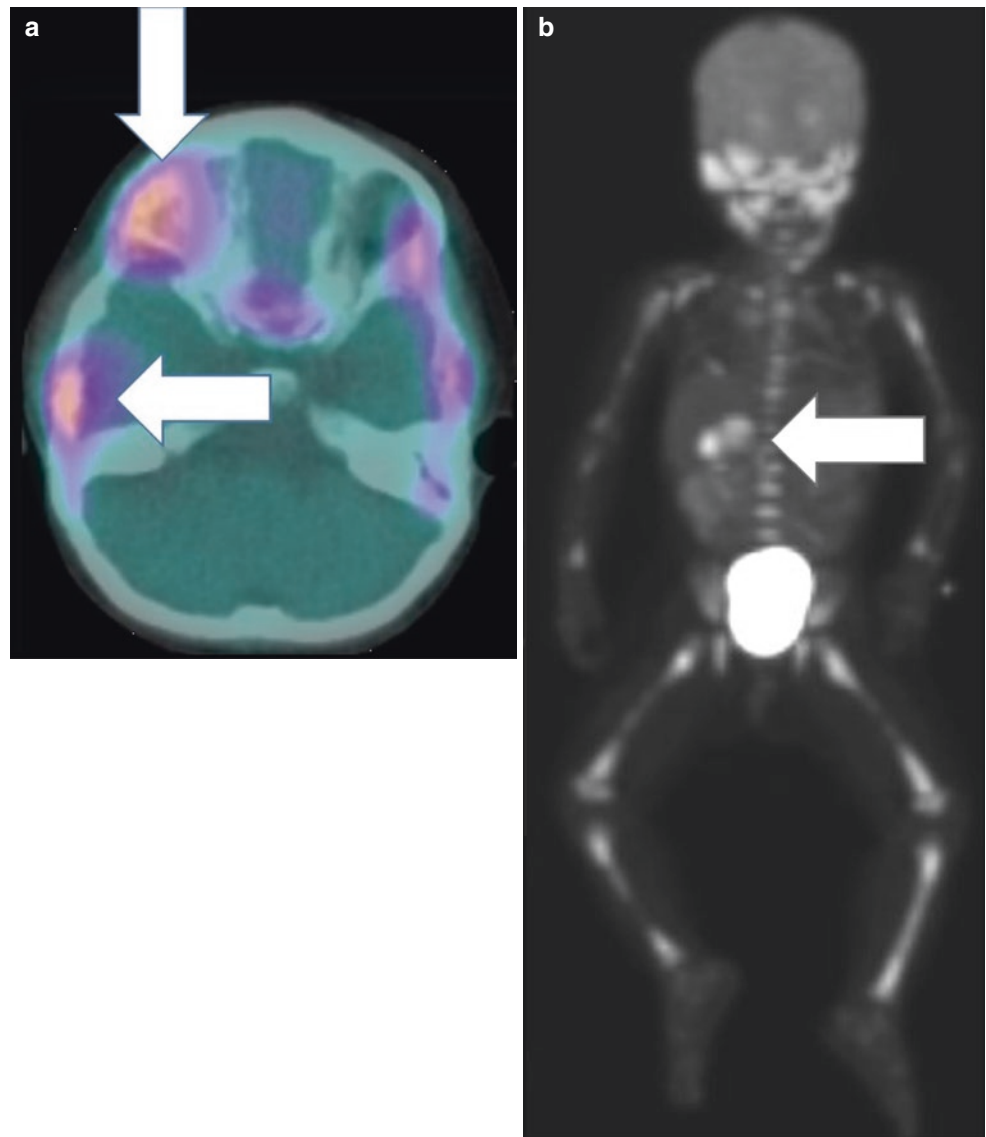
(a) Axial PET-CT scan shows abnormal bone activity in the roof of the orbit and temporal bone (arrows). (b) Coronal PET scan shows the primary suprarenal tumour (arrow) and multiple osseous deposits
